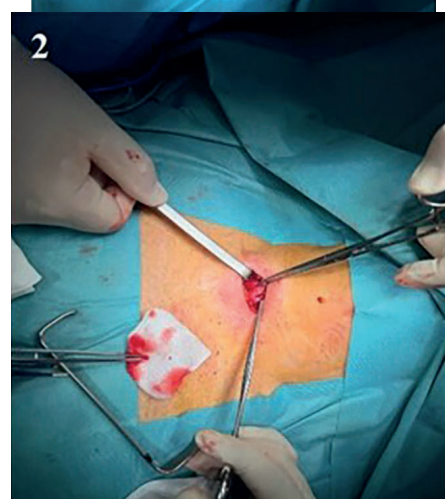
In our institution we adopt the minimally invasive technique which allows for small incisions targeted on the hyperproductive gland identified through preoperative scintigraphy and confirmed through interoperative PTH assay after removal. Figure 1 demonstrates the incision line for the inferior right parathyroid adenoma. Figure 2 demonstrates the size of the minimal surgical site due to precision information. Figure 3 demonstrates the final extracted adenoma.
